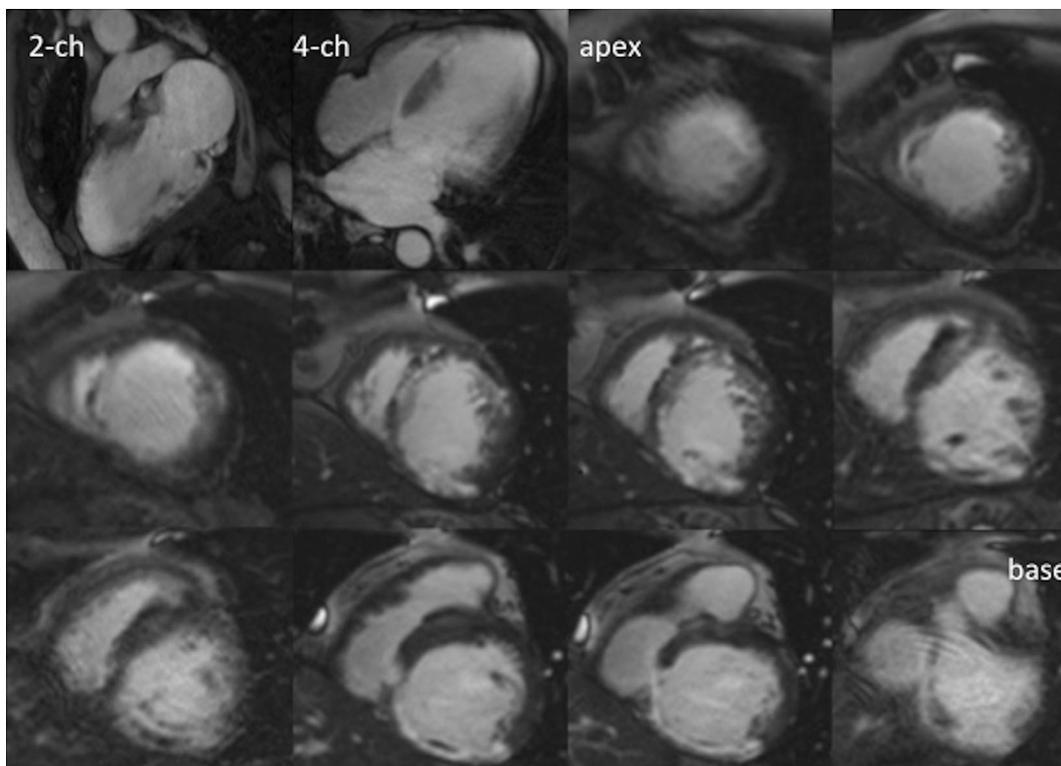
Assessment of myocardial viability by short-axis image Inversion-recovery prepared T1-weighted 2D gradient-echo sequence 10 minutes after intravenous administration of a gadolinium chelate (Dotarem; Guerbet, Roissy CdG Cedex, Paris, France).
